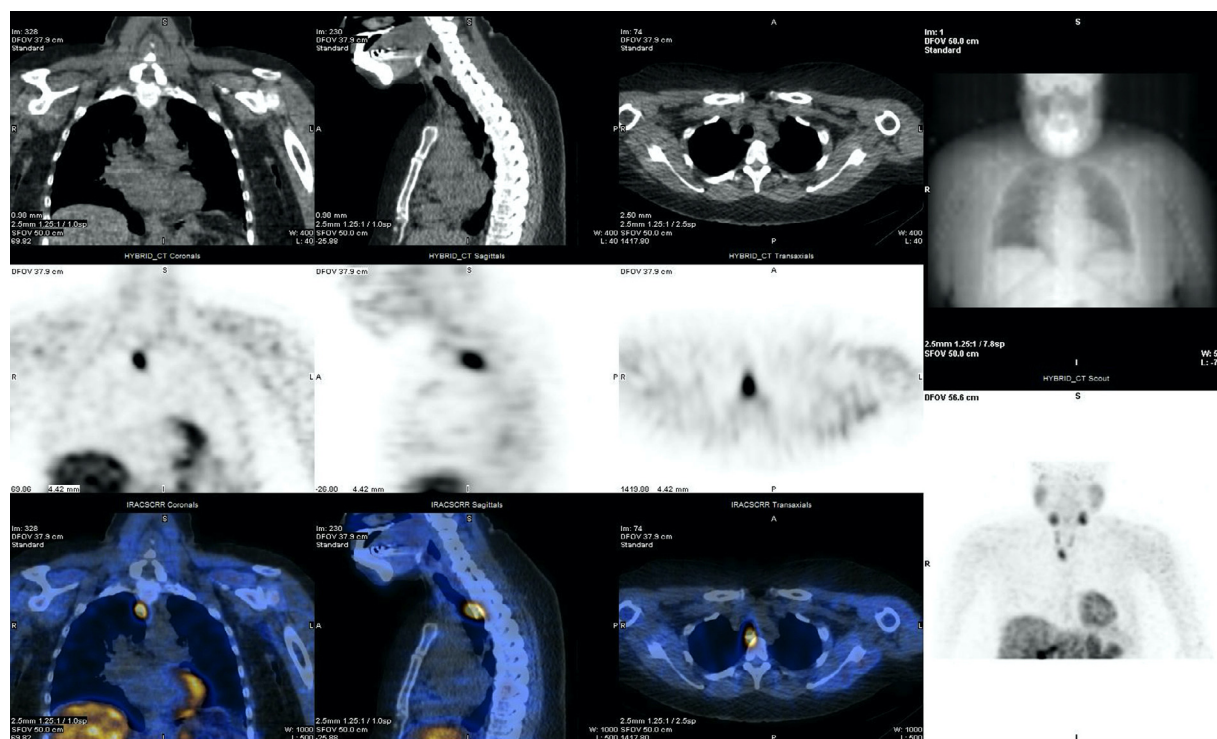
SPECT-CT following the administration of 16.0 mCi of ^{99m}Tc -Sestamibi with reconstruction in the three standard orthogonal planes demonstrates focal sestamibi uptake in the midline retrotracheal region, separate from the right lateral aspect of the esophagus.
